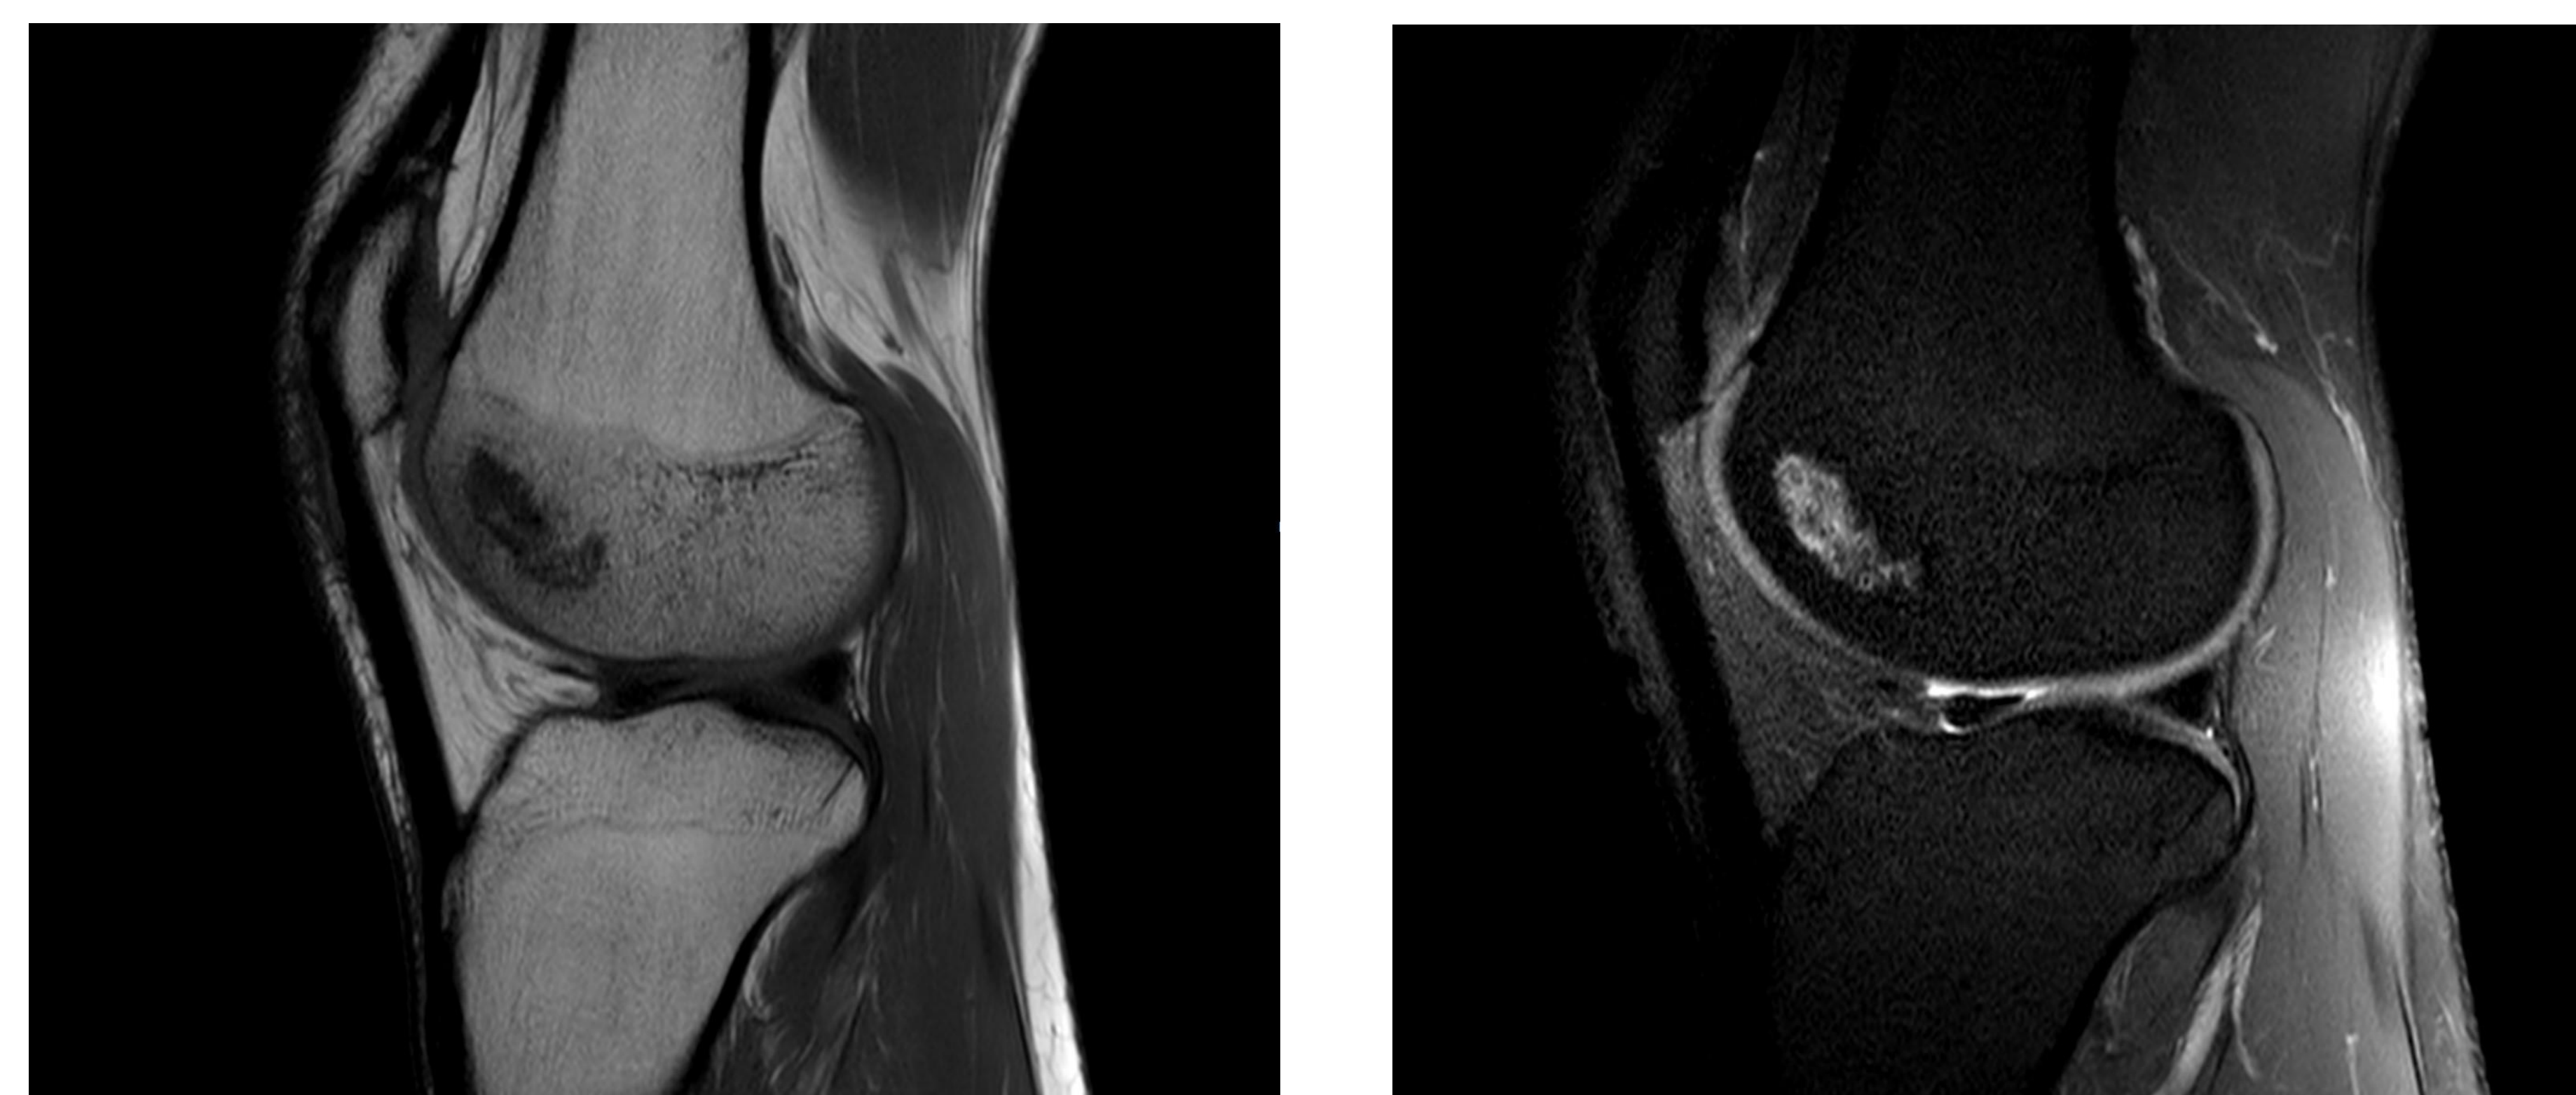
MRI T1 (left) and Proton Density (right) sagittal views of the right knee demonstrate a well circumscribed area of abnormal signal within the lateral femoral condyle, consistent with bone infarction.
